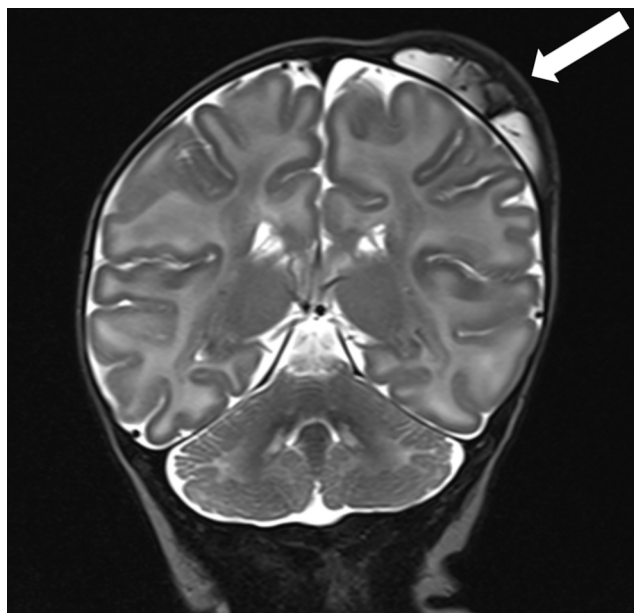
T2-weighted MRI showing the cephalhematoma (arrow) on the outside of the skull with no underlying intra-cranial hemorrhage.
